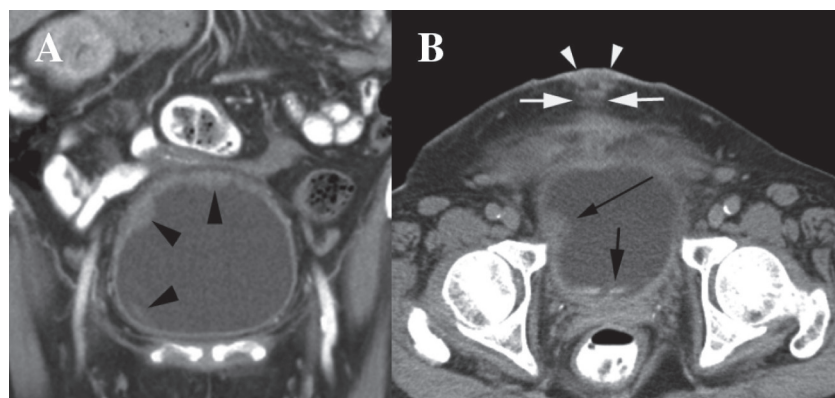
(A) Coronal reconstructed CT of the urinary bladder. Irregular enhancing thickening of the walls of the urinary bladder at the dome & right lateral base are shown (arrowheads). (B) Axial contrasted CT of the base of the urinary bladder at the level of the superior tip of greater trochanters. Heterogeneously enhancing soft tissue is seen extending in a linear pattern from the anterior wall of the bladder base, through the prevesical space, rectus sheath, the subcutaneous fat (short white arrows) and leading towards a heterogeneously enhancing mass anteriorly (white arrowheads) at the skin. A mass at the right lateral wall of the urinary bladder is shown (long black arrow). Contrast layering from the right ureteric orifice is indicated (short black arrow).
